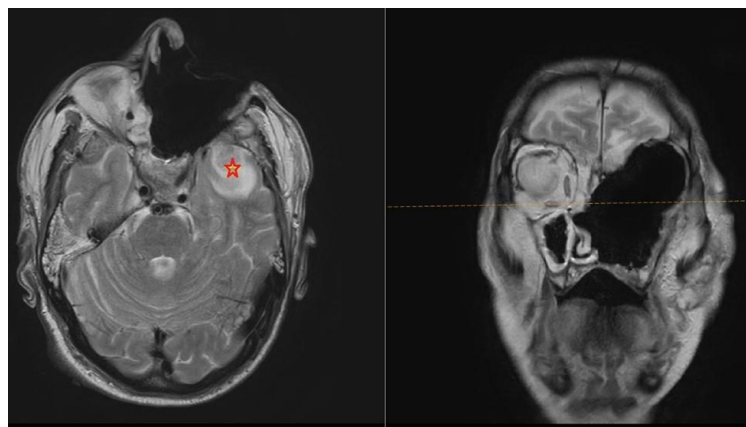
MRI brain of Case 2 (after debridement). The star indicates the increase in the size of the left temporal lesion.
